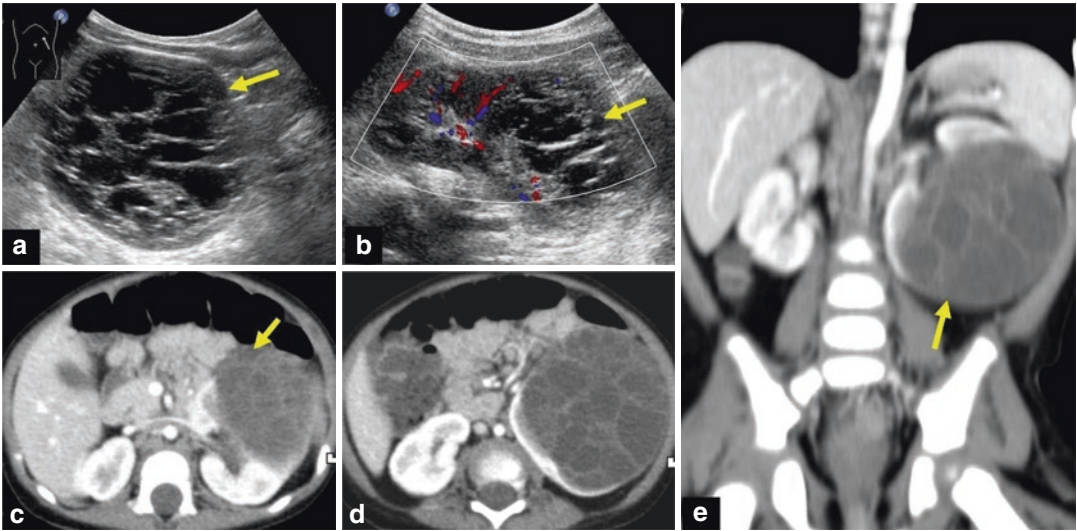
Multilocular CN in a 14-year-girl with non-tender left renal lump. USG gray scale and color Doppler images (a, b) show a well-encapsulated, avascular multilocular cystic mass in the left kidney. CECT images axial (c, d) and coronal MPR (e) show a well-circumscribed
